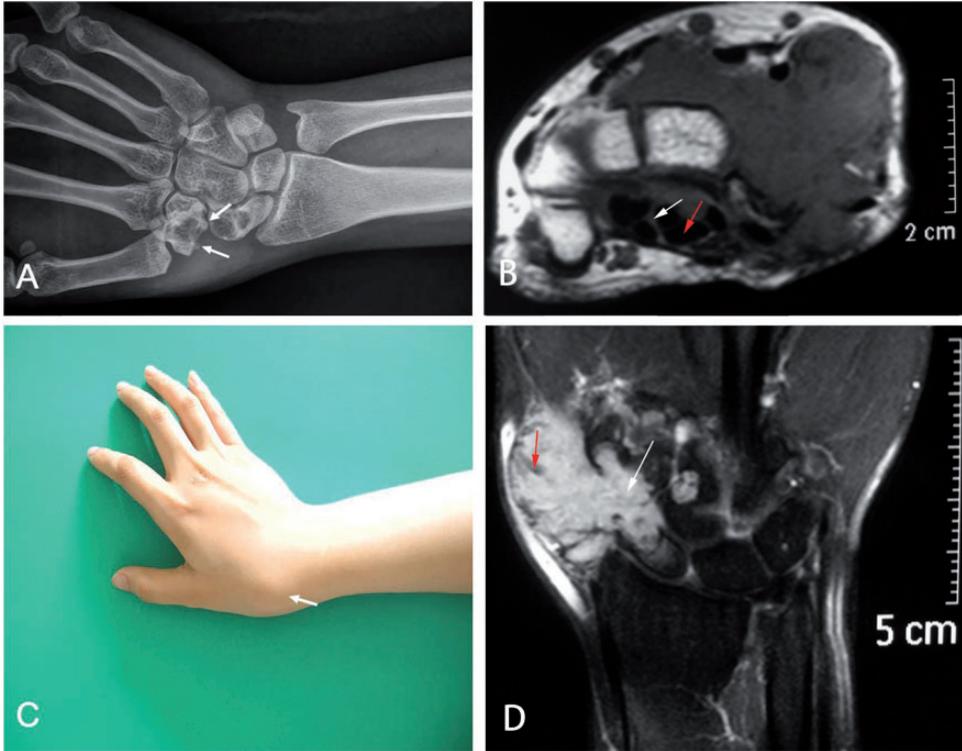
Clinical presentation of the mass (A). Plain radiograph showing osseous deformation (white arrows) of the dorsal aspect of the scaphoid and trapezium with associated diffuse soft tissue swelling and no underlying periosteal reaction (B). Axial spin-echo T1-weighted magnetic resonance (MR) image (TR 450/TE 11) shows low-to-intermediate soft tissue mass (white arrow) arising in the abductor pollicis longus tendon with a low-signal focus (red arrow) at its lateral aspect representing haemosiderin deposits. Erosions of the scaphoid, capitates, trapezium and trapezoid are well demonstrated (C). Coronal spin-echo T2-weighted image (TR 500/TE 11) shows moderate enhancement of the mass (white arrow), except for the tiny low signal foci (red arrow) (D). The colour version of this figure is available at: <http://imr.sagepub.com>.
